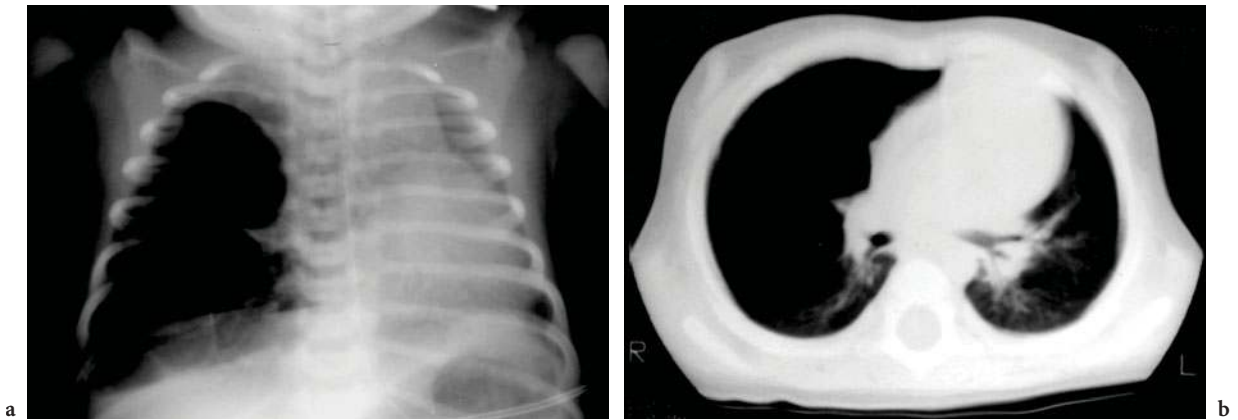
Cystic adenomatoid malformation. a Multiple cysts expand part of the right middle lobe. b CT same baby shows mass with multiple air-filled cysts
